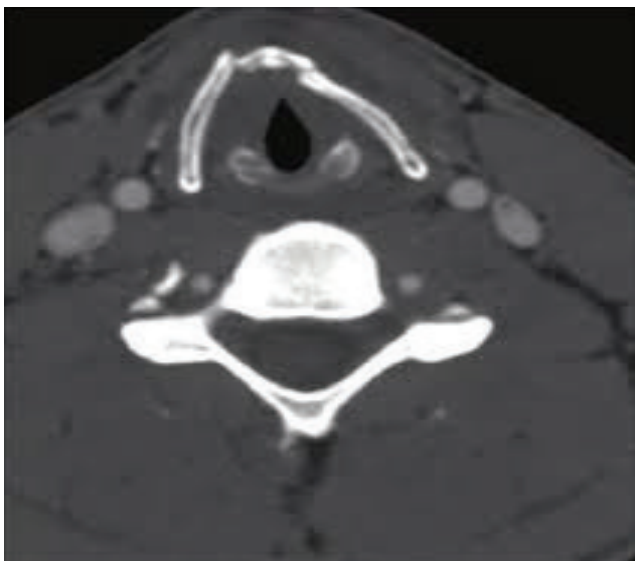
Imaging studies, including head and neck CT scans
